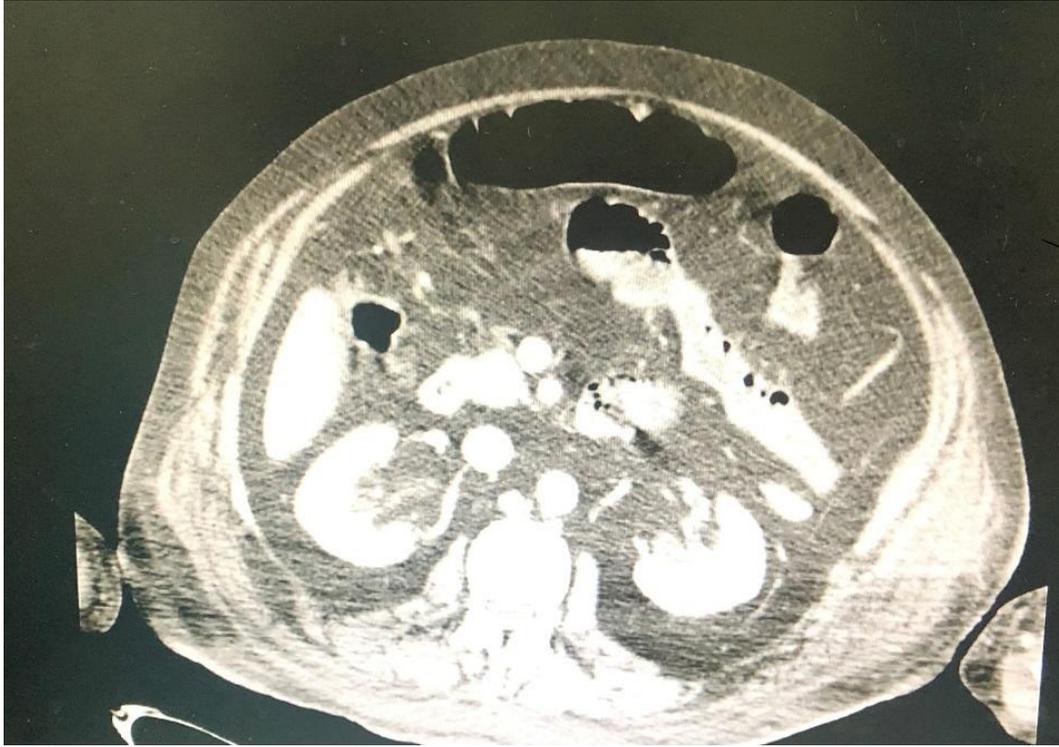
Showing CT-Abdomen of the patient with dilated proximal loops and collapsed distal loops S/O intestinal obstruction
